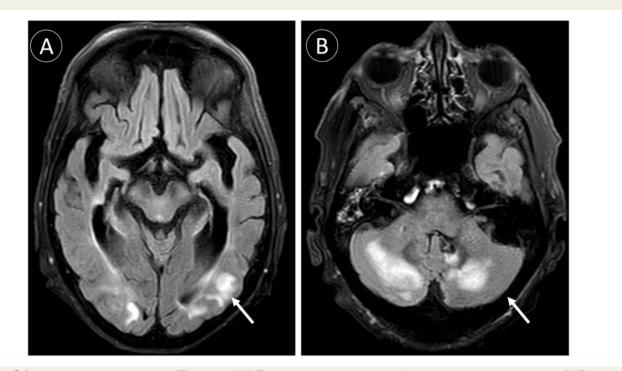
Brain magnetic resonance imaging (T2 weighted). (A) The arrow indicates vasogenic oedema in the posterior cerebral lobe. (B) The arrow indicates vasogenic oedema in the cerebellum.
